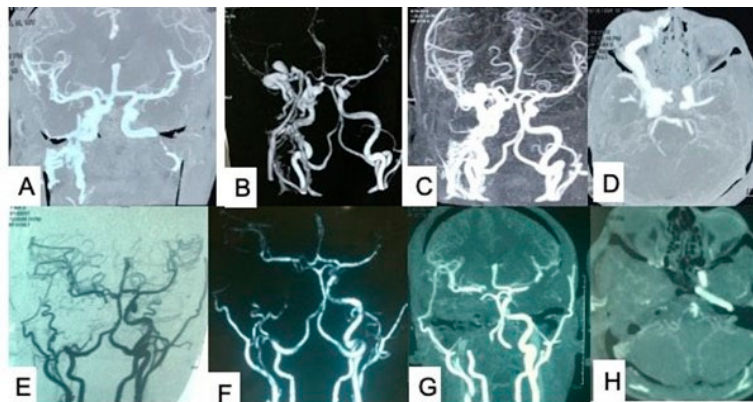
(A–D) Preoperative CTA showing a right-sided direct CCF. (E–H) CTA on the first POD after an STA–MCA bypass and ICA trapping. Source: Figure by authors.
